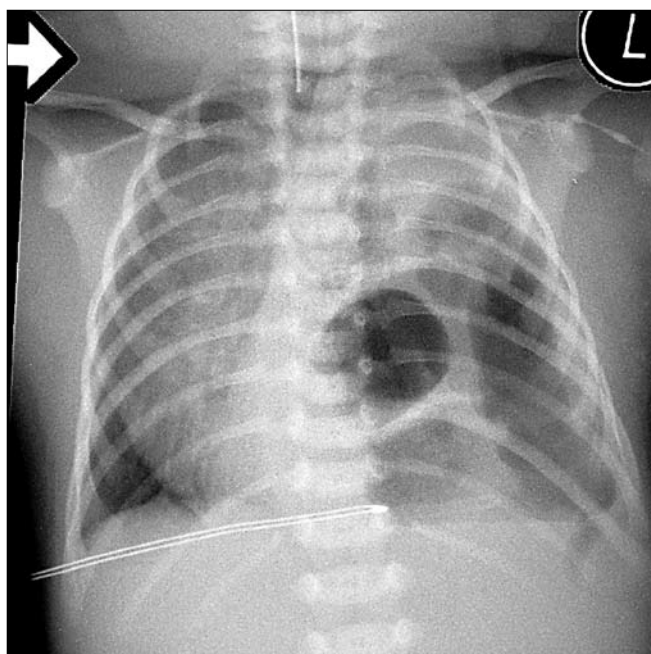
Chest x-ray immediately after birth.
